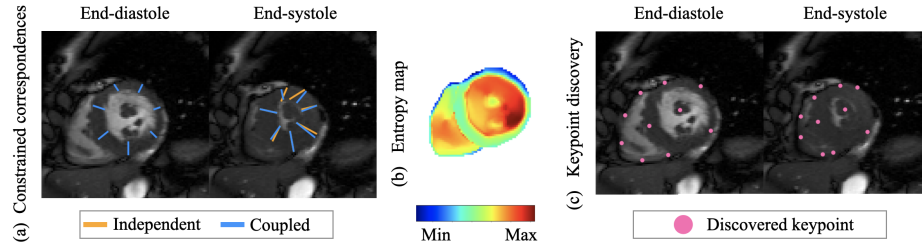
(a) Constrained correspondence estimation on cardiac MRI with independent versus coupled results. Unsupervised keypoint discovery on cine cardiac MRI with (b) the corresponding entropy map and (c) the discovered salient keypoints.
